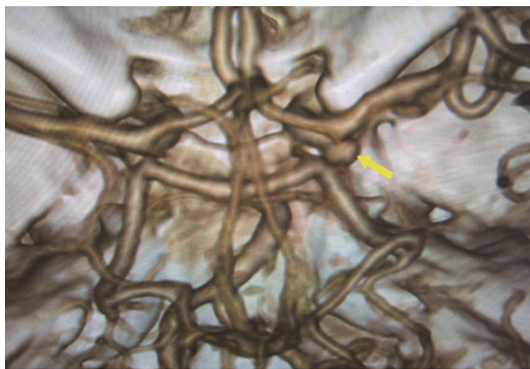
Computed tomography angiography showing an aneurysm located at the proximal end of the right posterior communicating artery to internal carotid artery. The arrow indicates the aneurysm.
